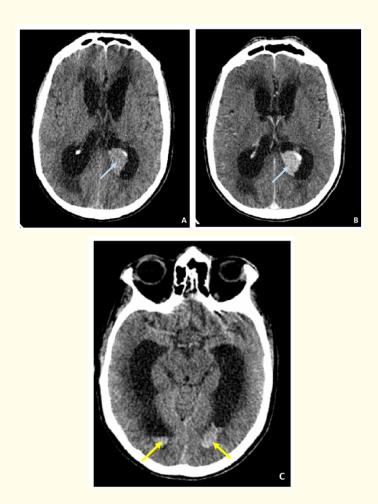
Axial of CT scan of head before (A) and after enhancement (B and C) revealing a well-circumscribed mass in left lateral ventricle that homogenously enhanced (blue arrows) with hydrocephalus and intraventricular bleeding (yellow arrows).
